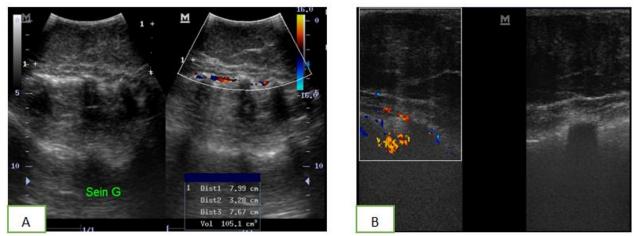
Ultrasound images, B mode and color Doppler mode, with convex (A) and linear (B) probes: Well-delineated oval left breast mass, with long axis parallel to the skin plane, heterogeneous hypoechoic with some echogenic spots, and moderate posterior ultrasound enhancement. Absence of significant arteriovenous vascularization on Doppler
